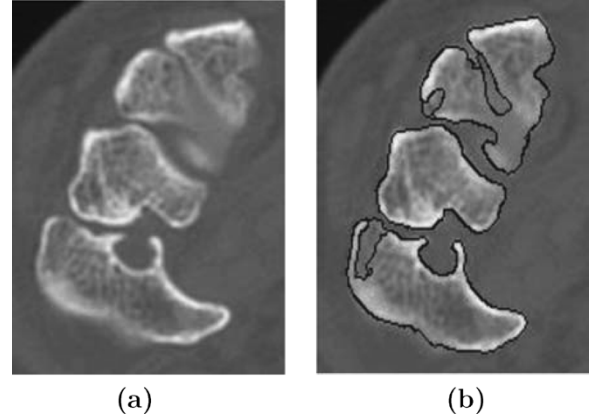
(a) One blurred CT slice of a human wrist. (b) The edge map of the slice obtained by our algorithm.
